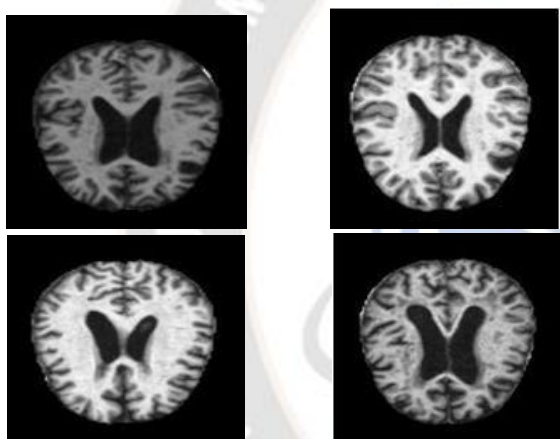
Classes labels of Alzheimer's disease severities given by MRI scan images
